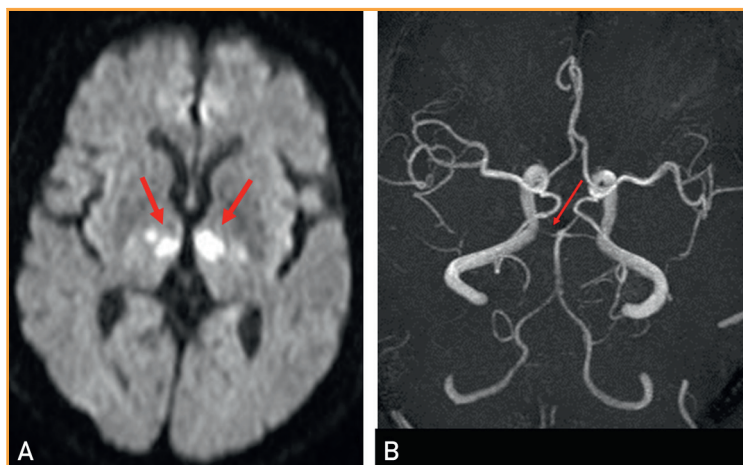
A, Diffusion-weighted image obtained by performing cranial magnetic resonance imaging showing bilaterally symmetric high-signal intensity in the thalamus (red arrows). B, Cranial magnetic resonance angiogram showing blockage of the right thalamoperforating artery (red arrow).
